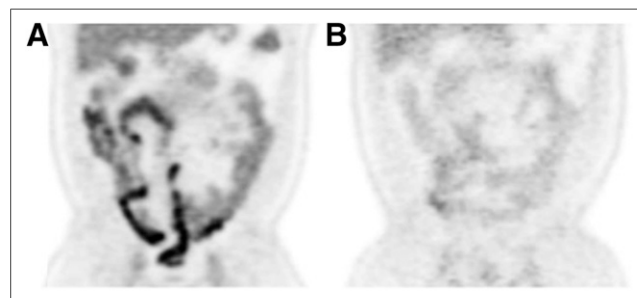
Effect of metformin on intestinal ^{18}F -FDG uptake. (A) Coronal ^{18}F -FDG PET image of diabetic patient while on metformin demonstrates prominent bowel activity. (B) Prior ^{18}F -FDG PET study of same patient while not on metformin shows only mild tracer activity in bowel.
